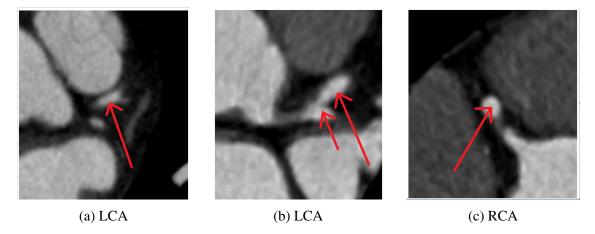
Coronary visualization with respect to the background on axial planes for three different CTA volumes. It can be observed that due to the contrast filled blood, the coronary vasculature appears brighter than the background for all three volumes.
